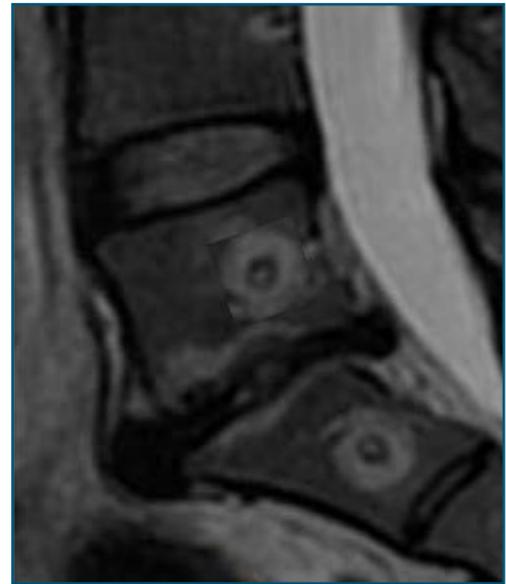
MRI 6 weeks post ablation of the L5 and S1 basivertebral nerves.
